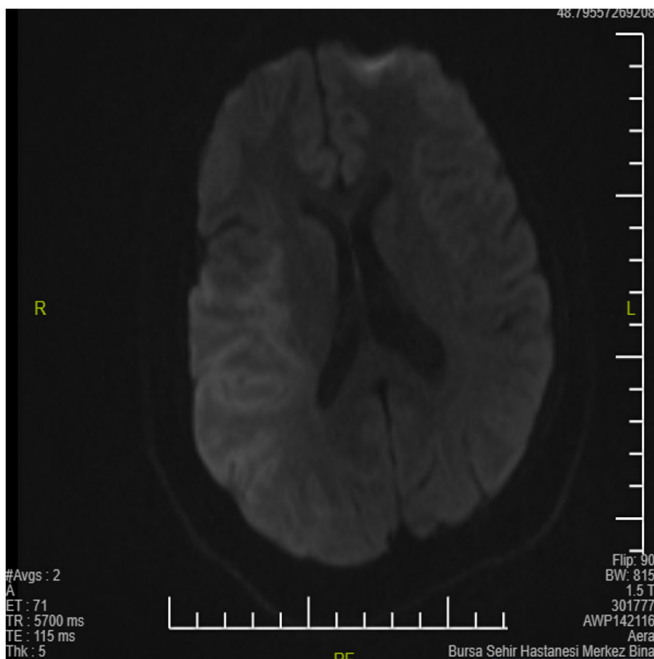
First diffusion magnetic resonance imaging sequence
